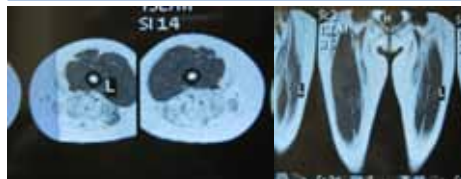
MRI of the thigh muscles in a patient with GNE myopathy
